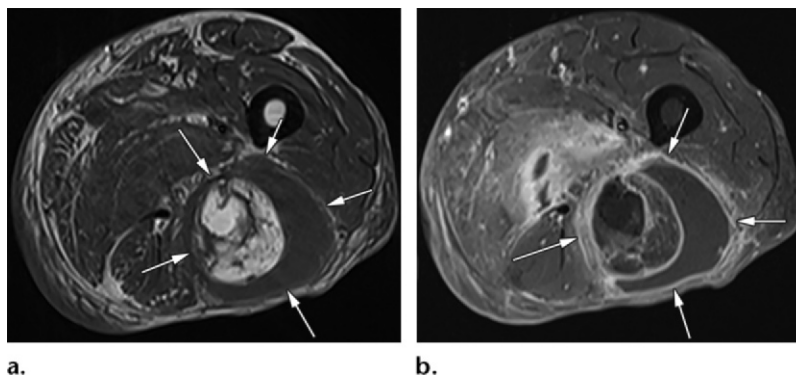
Fat necrosis in a 60-year-old man with left leg pain and swelling. (a) Axial T1-weighted MR image shows a heterogeneous mass (arrows) within the posterior compartment of the left thigh with a lobulated hyperintense component centrally suggesting the presence of fat with a peripheral hypointense component. (b) Axial postcontrast fat-saturated T1-weighted MR image shows suppression of the fat signal intensity of the mass (arrows), an adjacent peripheral rim-enhancing collection, and heterogeneous enhancement within the adjacent muscles.
